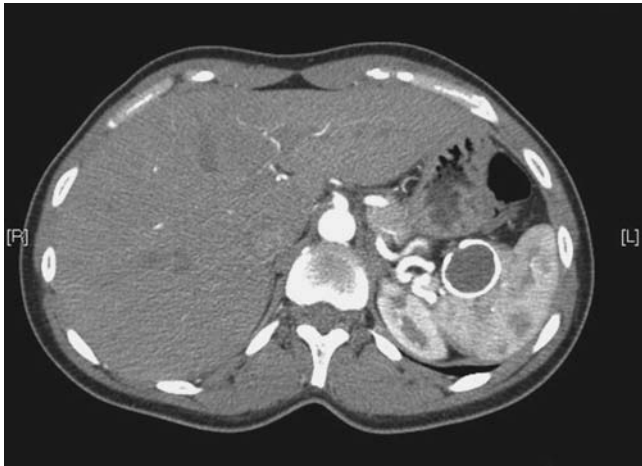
A CT scan of a large splenic artery aneurysm with calcified wall. This calcified wall can also be seen on plain abdominal roentgenogram.
